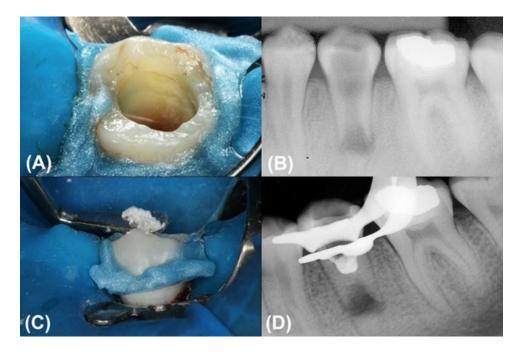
A. Initial image of tooth (#35). B. Radiographic image of atypical root formation with incompletely formed apex. C. Bioceramic material placement into the pulp cavity. D. Radiographic image taken after the treatment completion.
